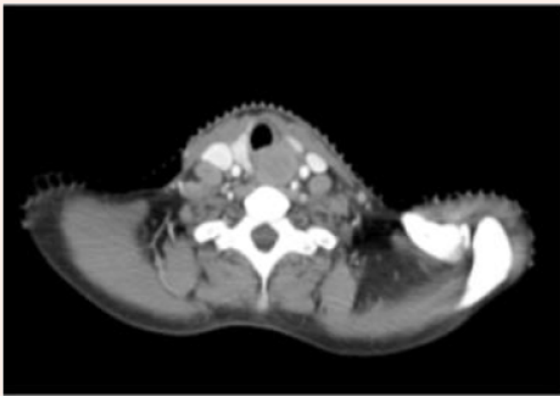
CT scan of Neck and Chest showed Circumferential Irregular thickening with Heterogenous enhancement noted in the Hypo-Pharyngeal-Oesophageal junction and enlarged bilateral level two Lymph nodes.
